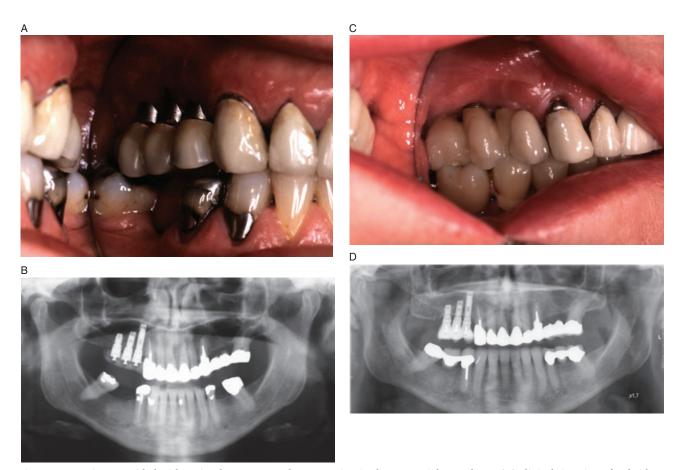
The same patient as in Figure 1A showing (A) the clinical situation after bridge attachment in 1984, (B) panoramic radiograph obtained after bridge attachment in 1984, (C) the clinical situation in May 2004 presenting the original bridge construction being supported by two implants (V1 and V2), and (D) panoramic radiograph taken at the 20-year follow-up control.
